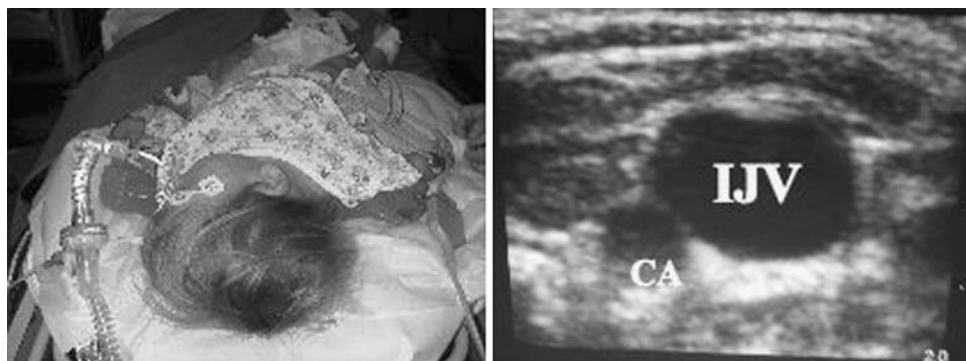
Patient with head turned at 45°, Ultrasound image shows right IJV more ellipsoidal and lateral to carotid artery
